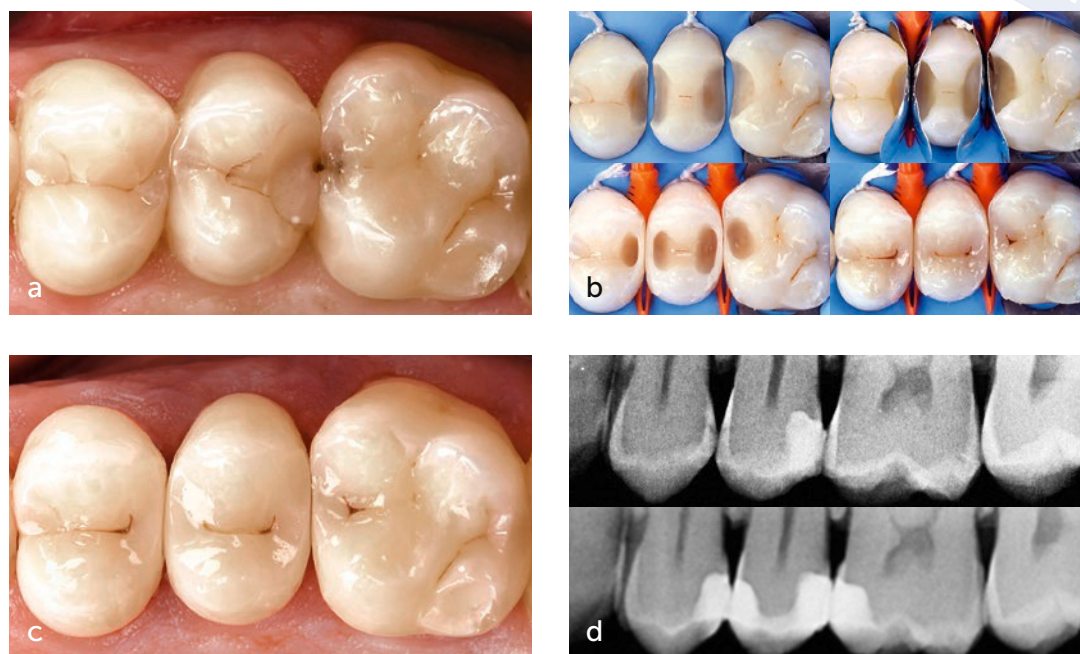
(a) Initial situation with caries on premolars and first molar. (b) Removal of carious tissue, removal of unsupported enamel, absent or shallow central cavities with remaining walls thicker than 1 mm – therefore, a direct adhesive restoration was performed. (c) Result at 3 years. (d) Radiographs of initial situation (top) and at the 3-year follow-up (bottom).
